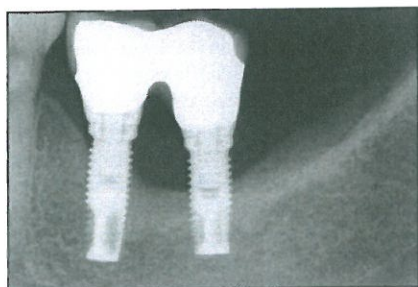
Preoperative peri-apical radiograph. Chief patient complaint: recurrent acute abscesses.
